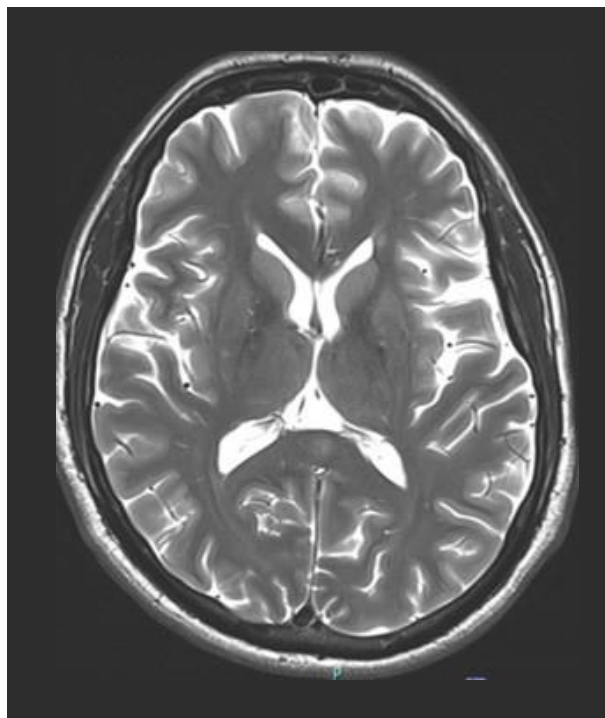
T2-weighted imaging
